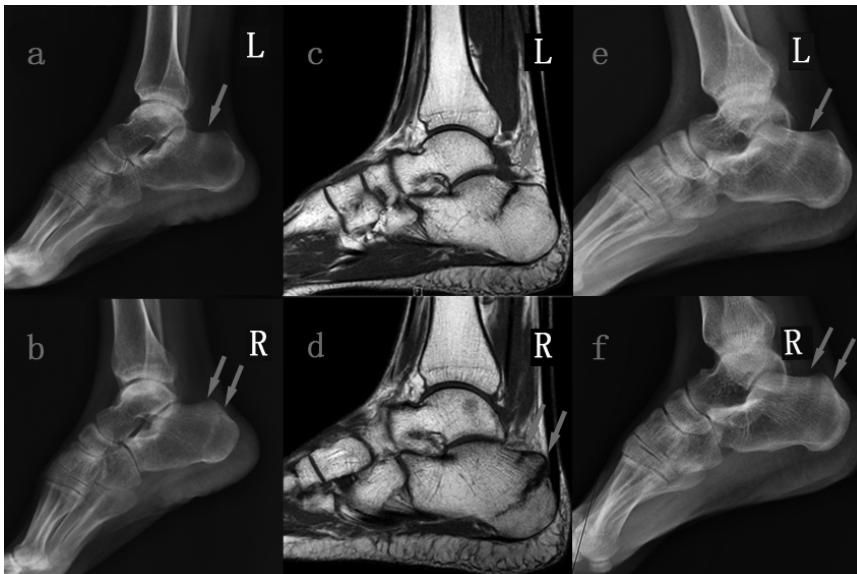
X-ray and magnetic resonance imaging showed bilateral pathological calcaneal occult fractures (Arrow). A and B) Radiographic osteopenia and a band of sclerosis between the calcaneal tuberosity and the posterior facet of the subtalar joint. C and D) Calcaneus marrow edema and fracture lines located in the same region of the band of sclerosis. E and F) A follow-up X-ray conducted 20 weeks after the withdrawal of adefovir dipivoxil showed increased bone mass and fuzzy fracture lines.*
